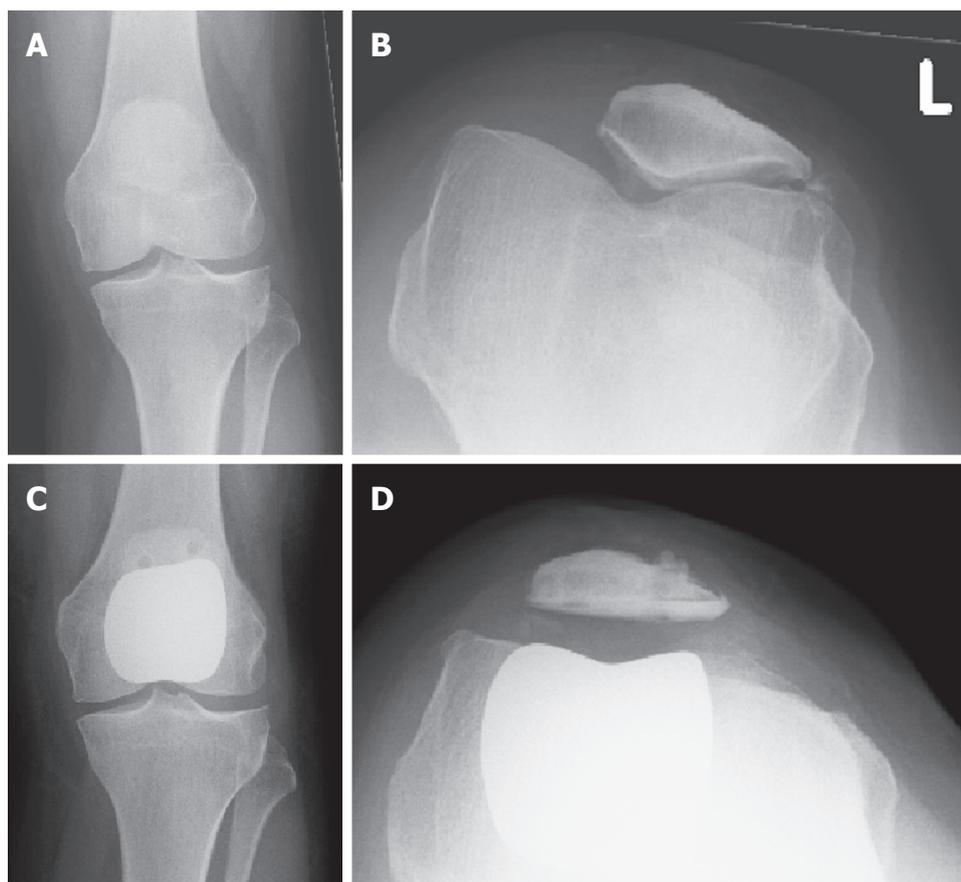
Preoperative and postoperative radiographs using the Femoro-Patella Vialla implant. Preoperative (A) weight-bearing anteroposterior, (B) skyline radiographs in a 60-year-old woman with severe patellofemoral degeneration and subluxation. Postoperative weight-bearing radiographs show satisfactory placement of the prosthesis on the (C) anteroposterior, and (D) skyline views of the same patient at 2 years.
